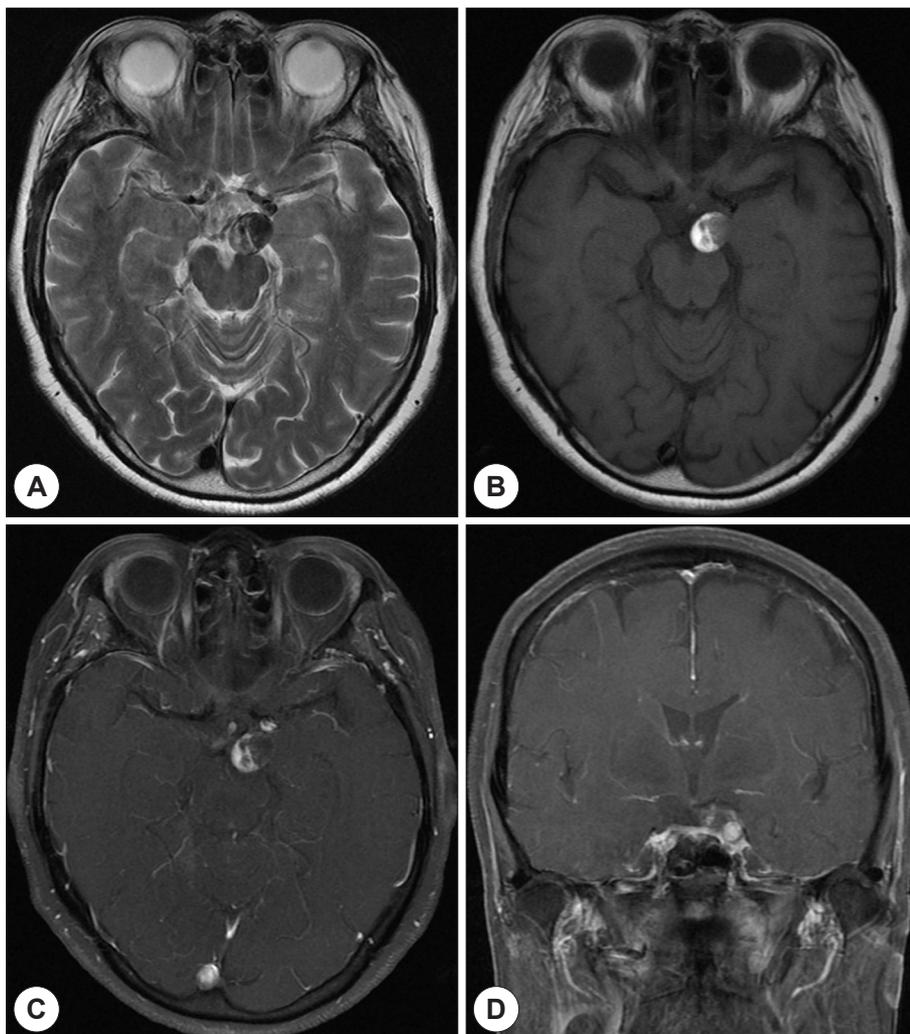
Brain magnetic resonance imaging reveals a heterogeneous low signal intensity on T2-weighted image (A), a high signal intensity on T1-weighted image (B) and a subtle contrast enhancement after gadolinium injection (C and D).
